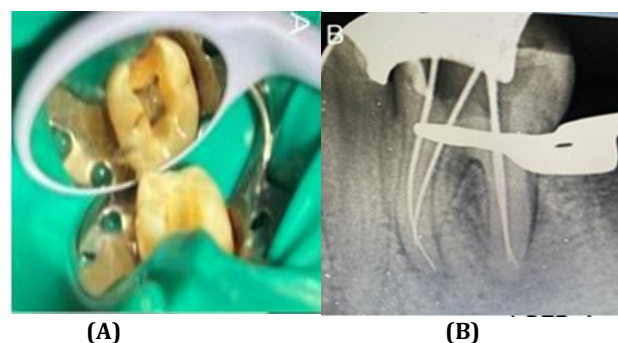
A) After completing the access, four orifices were identified. B) The initial File radiography indicates that the mesial root canals are classified as Type 2.
